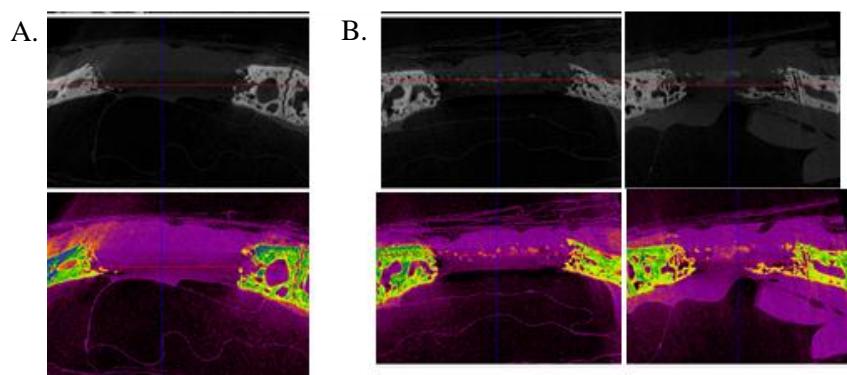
Micro CT images of fibrin applied defects at 4 weeks. A. Fibrin alone applied defect. B. Fibrin+TAT-BMP-2 5 μ g applied defects.
